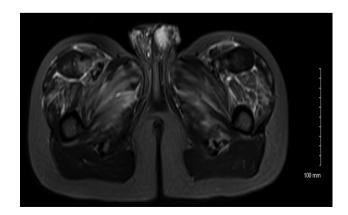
Magnetic resonance imaging (MRI) of thigh showing extensive oedema in anterior thigh compartment on T2-weighted imaging.
